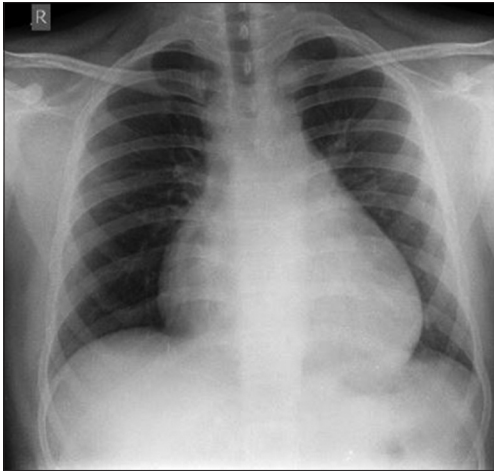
Chest X-ray showing pericardial effusion
